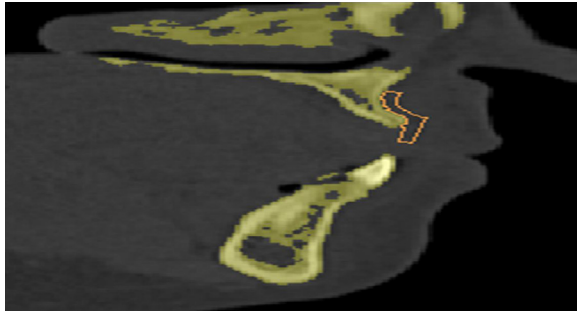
Preoperative cross-sectional view of a CT scan showing the deficient ridge.
